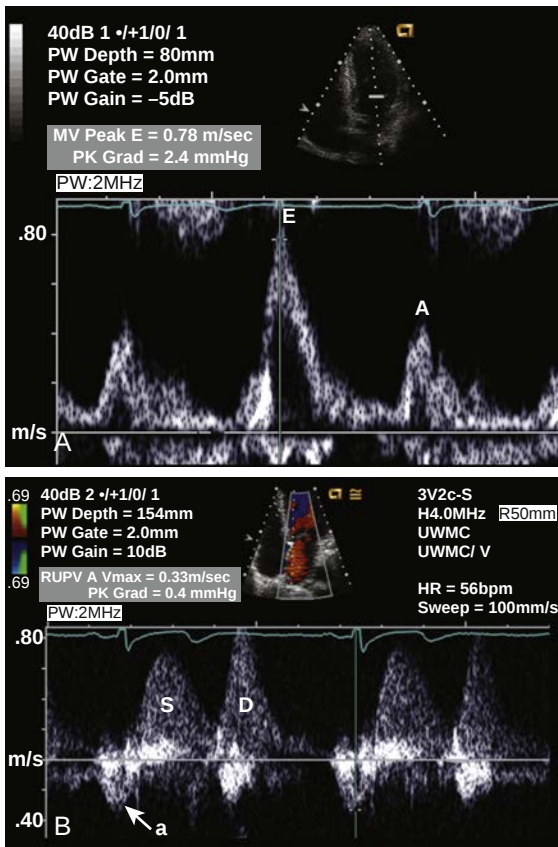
LV diastolic function. (A) LV inflow is recorded using pulsed Doppler with the sample volume positioned at the mitral leaflet tips in diastole. The typical early (E) diastolic filling velocity and atrial (A) velocity are seen. (B) Left atrial inflow is recorded with the pulsed Doppler sample volume in the right superior pulmonary vein in an apical 4-chamber view. The normal pattern of systolic (S) and diastolic (D) inflow with a small atrial (a) flow reversal are seen.
